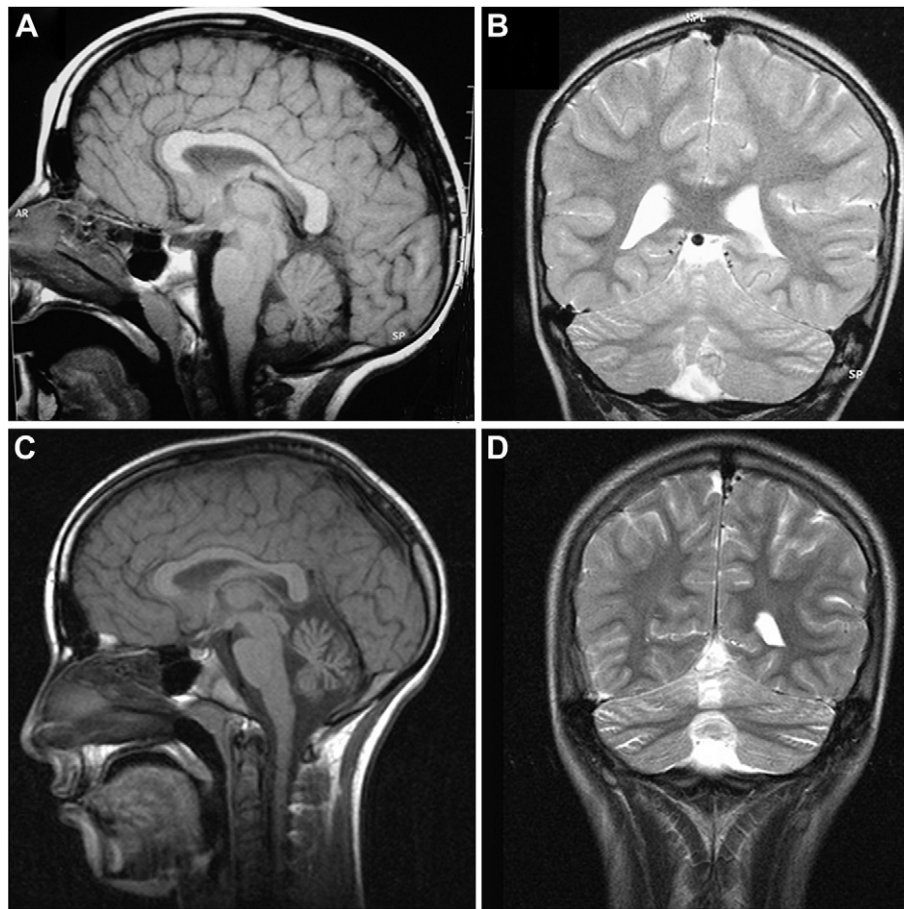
A–D. Brain MRI of patient CHA987 performed at age 7 (Fig. 2 A,B) and 13 years. In Fig. 2 A (sagittal, T1 weighted) and 2 B (coronal, T2 weighted) the atrophy is very mild while it is clearly evident and prominent at the vermis at a later age in Fig. 2 C (sagittal, T1 weighted) and 2 D (coronal, T2 weighted).
